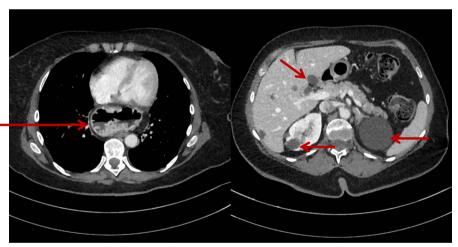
Abdominal CT scan showing a polycystic hepatorenal disease and hiatal hernia, with no abnormalities of the pancreatic parenchyma
